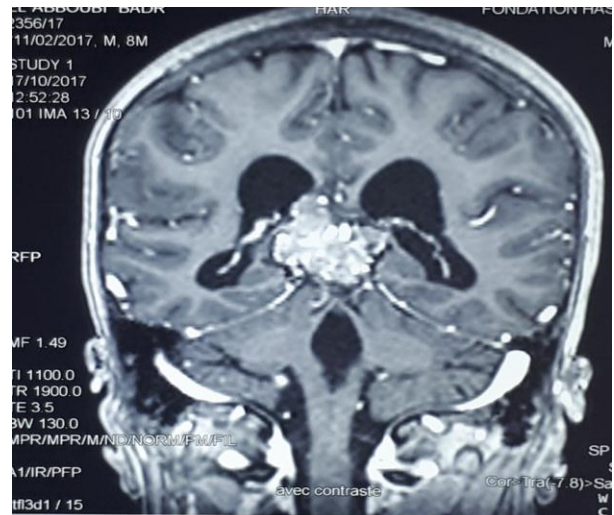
Post-chemotherapy enhanced coronal MRI scans showing the tumor in the pineal region.
